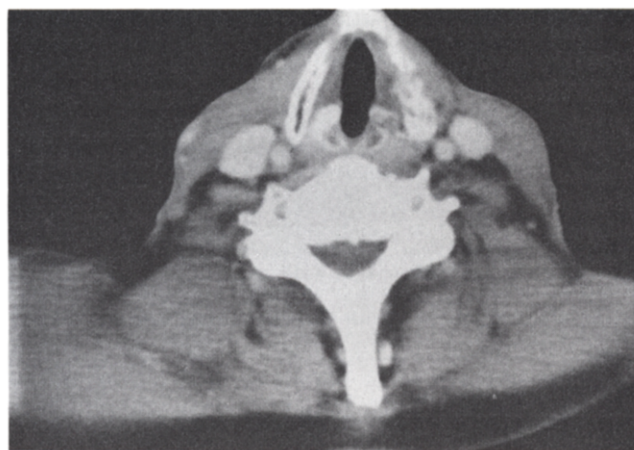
Computed tomography scan at a slightly higher level 3 months after radical dose external beam radiotherapy showing previous tumour damage of the left thyroid cartilage and complete resolution of soft tissue mass.
